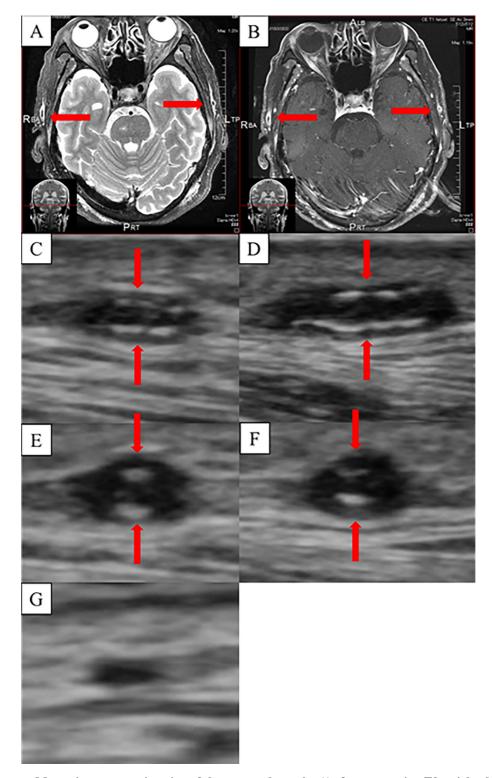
Magnetic resonance imaging of the temporal arteries (A: fat suppression T2-weighted image. B: fat suppression and contrast-enhanced T1-weighted image) showed arterial wall thickness and abnormal contrast enhancement (indicated by arrows). Ultrasonography (C: right, longitudinal. D: left, longitudinal. E: right transverse. F: left transverse) of the temporal arteries revealed hypoechoic halo (halo sign). The arrows indicate the sites of inflammation. The halo sign improved after treatment (G: right transverse).
